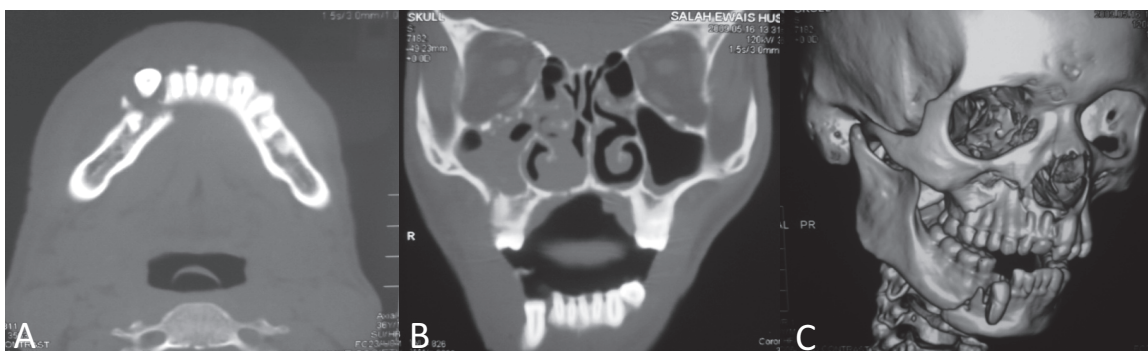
(A) Axial CT scan bone window reveals two fracture lines extending mesial and distal to tooth #43. (B) Coronal CT scan bone window reveals fracture of inferior wall of right orbit and lateral wall of right maxillary sinus, as well as right hamosinus, two air locules and intruded tooth #43. (C) R3D-CT scan reveals fracture of anterior wall of maxillary sinus as well as right parasymphseal fracture.
